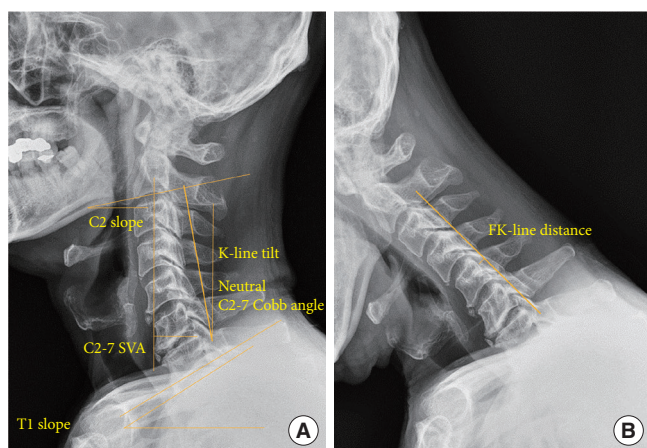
Measurement of radiologic parameters. (A) Sagittal alignment parameters: C2 slope (angle between the inferior endplate of C2 and the horizontal plane), T1 slope (angle between the superior endplate of T1 and the horizontal plane), C2–7 Cobb angle (angle between the inferior endplates of C2 and C7), C2–7 sagittal vertical axis (SVA; horizontal distance from the centroid of C2 to the posterior-superior corner of C7), and K-line tilt (angle between the K-line and a line perpendicular to the horizontal plane). (B) FK-line distance, defined as the shortest distance between the flexion K-line and the posterior border of the nearest vertebral body on a lateral flexion radiograph in patients with ossification of the posterior longitudinal ligament.
